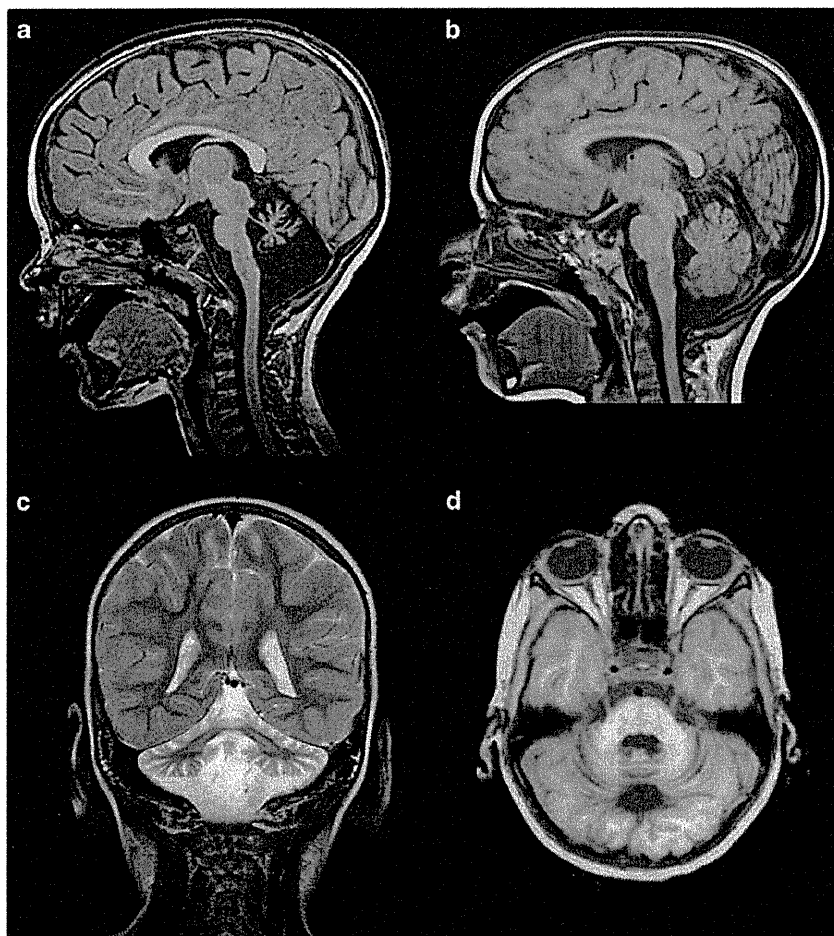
The brain MRI of the patient with p.Q2202del showing pontocerebellar atrophy. (a) Sagittal T1 image at midline showing severe atrophy of vermis with hypoplastic brainstem. The corpus callosum is larger than normal for the age of the patient. (b) Sagittal T1 image of an age and gender matched control showing normal pons and normal cerebellum (c) Coronal T2 image of the patient at the level of the posterior fossa, showing severe atrophy of both cerebellar hemispheres with T2 hypersignal of both middle cerebellar peduncle. (d) Axial T1 image of the patient at the level of the cerebellum showing diffuse cerebellar atrophy.
